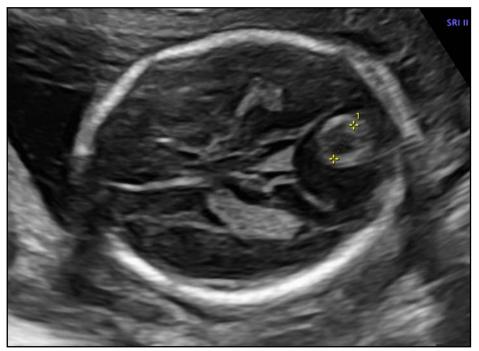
The initial ultrasound at 21 weeks and 5 days. There is a torcular lake above the posterior fossa with visible thrombus of 9mm.
